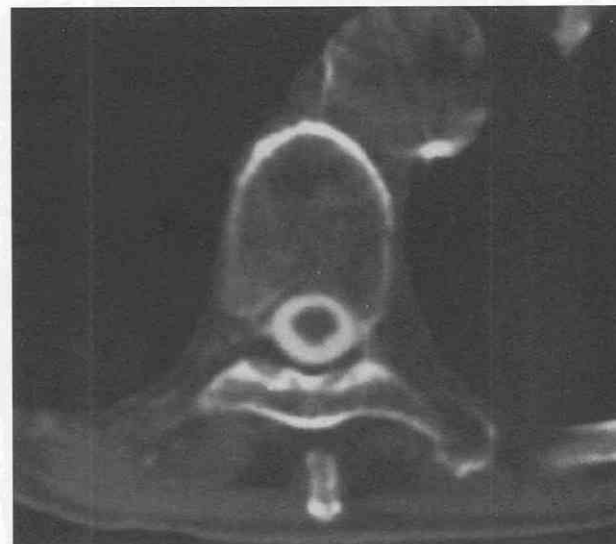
Normal postmyelogram thoracic CT scan. Note the round shape of the normal thoracic cord and canal.
